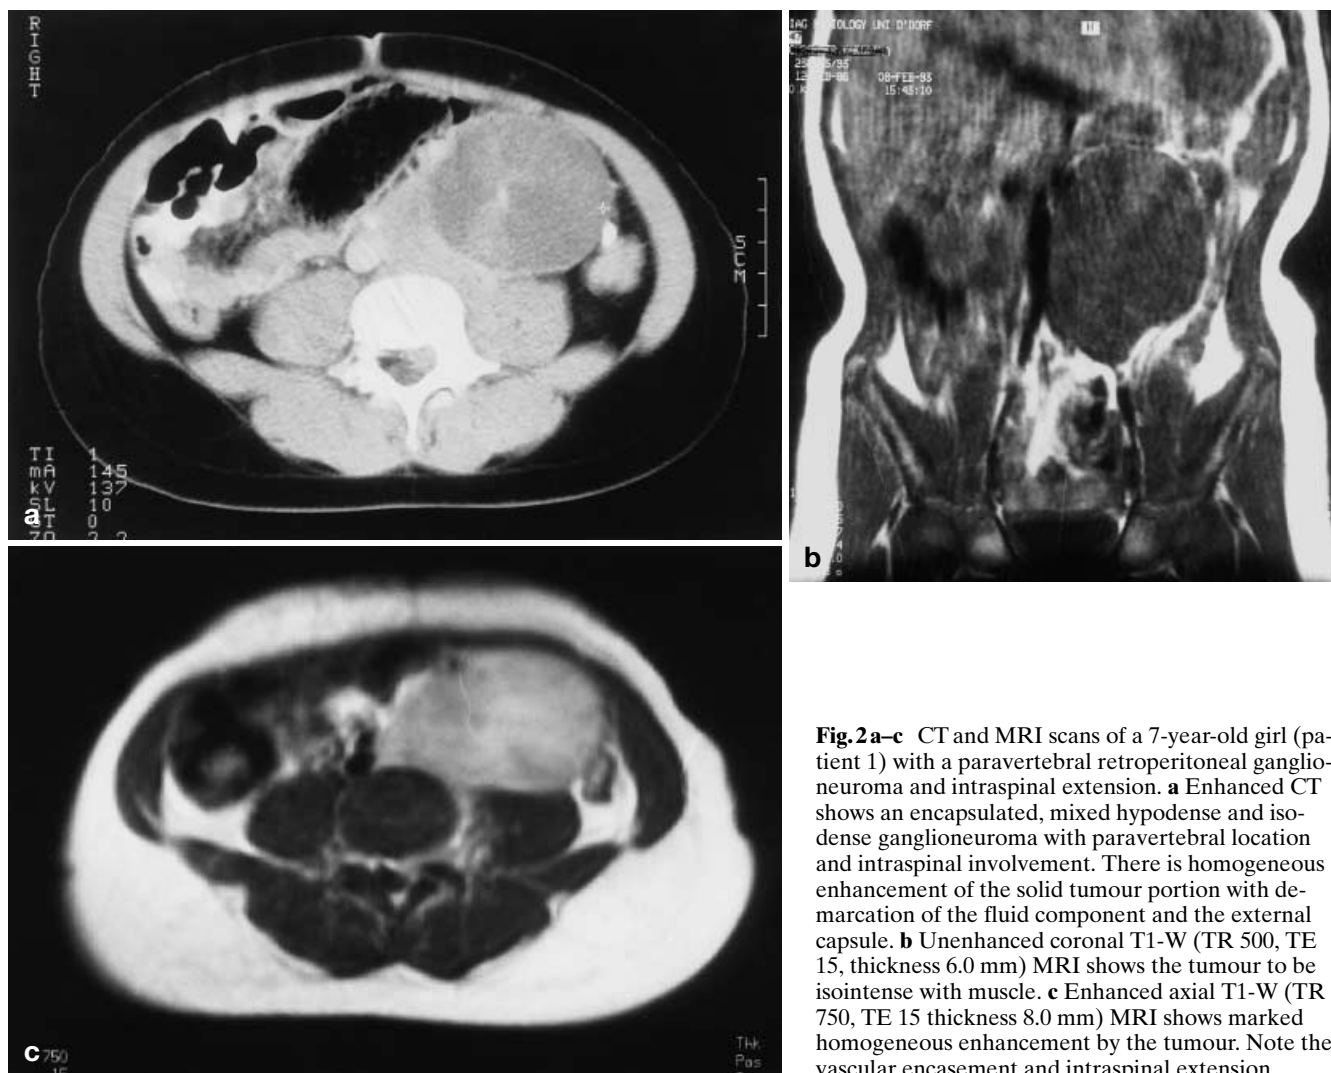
CT and MRI scans of a 7-year-old girl (patient 1) with a paravertebral retroperitoneal ganglioneuroma and intraspinal extension. a Enhanced CT shows an encapsulated, mixed hypodense and isodense ganglioneuroma with paravertebral location and intraspinal involvement. There is homogeneous enhancement of the solid tumour portion with demarcation of the fluid component and the external capsule. b Unenhanced coronal T1-W (TR 500, TE 15, thickness 6.0 mm) MRI shows the tumour to be isointense with muscle. c Enhanced axial T1-W (TR 750, TE 15 thickness 8.0 mm) MRI shows marked homogeneous enhancement by the tumour. Note the vascular encasement and intraspinal extension
